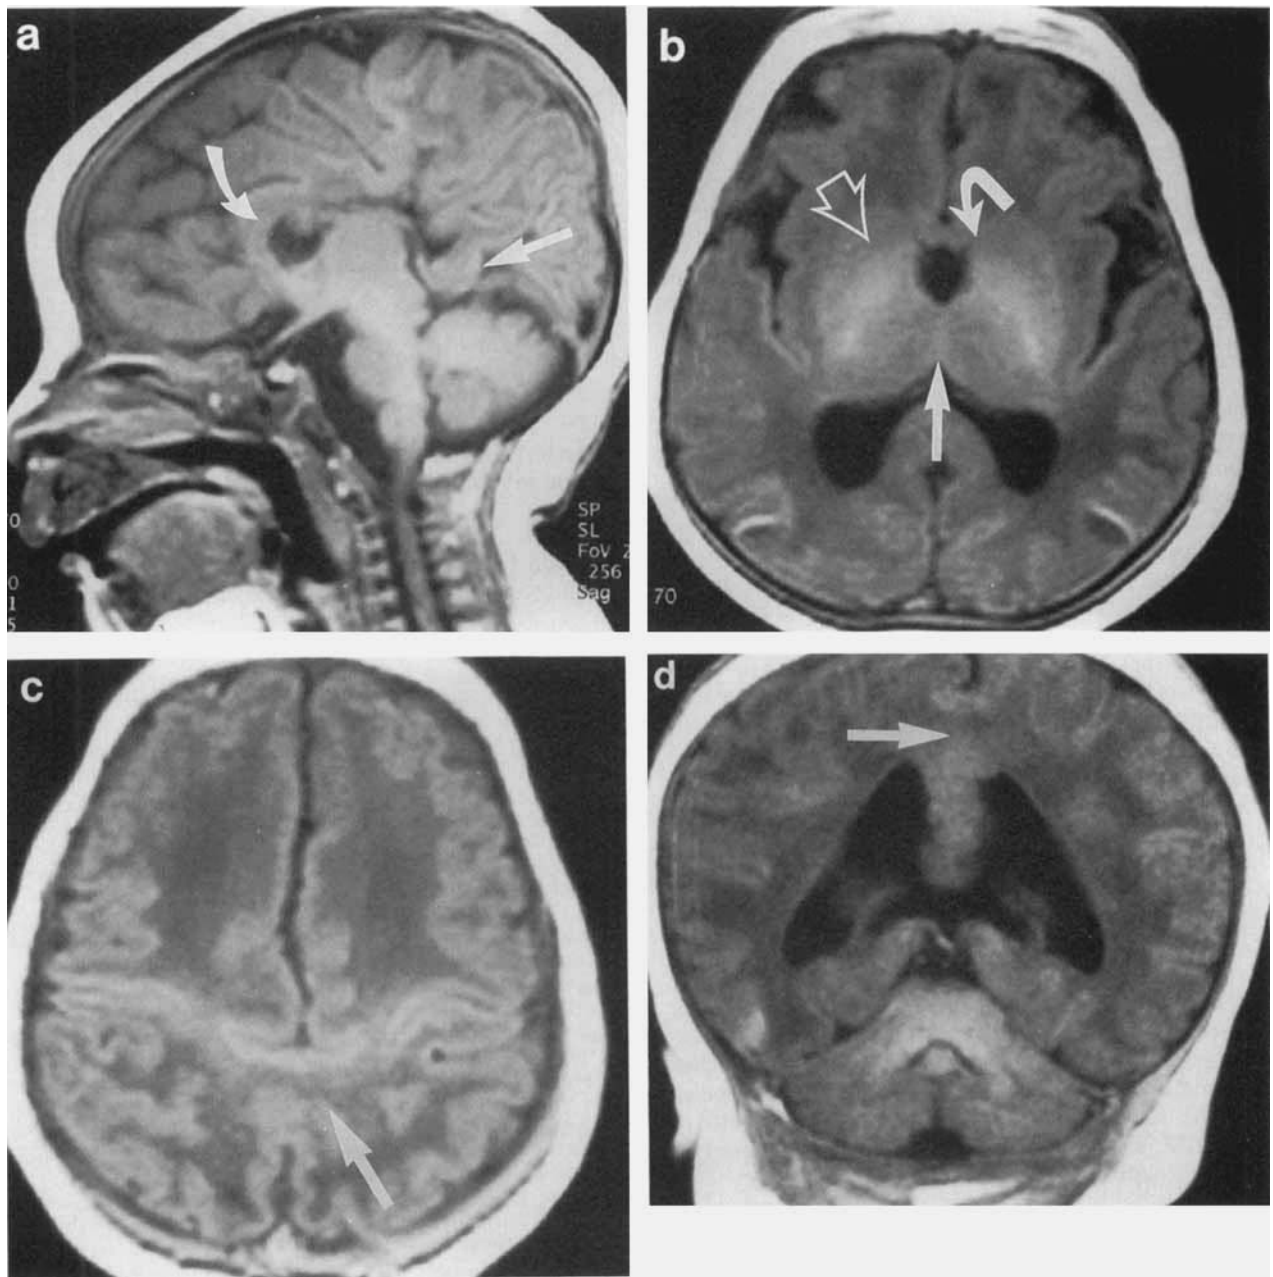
a: T1 weighted sagittal MRI images demonstrating the genu of the corpus callosum (curved arrow) as well as a splenium-like structure posteriorly (straight arrow). b: T1 weighted axial image demonstrating hypoplastic frontal horns (curved arrow), and striatal (open arrow) as well as thalamic (straight arrow) "fusion". c: T1 weighted axial image demonstrating partial "fusion" of the hemispheres near the parietal convexity (arrow). d: T1 weighted coronal image also demonstrates the midline "fusion" in the parietal region (arrow).
